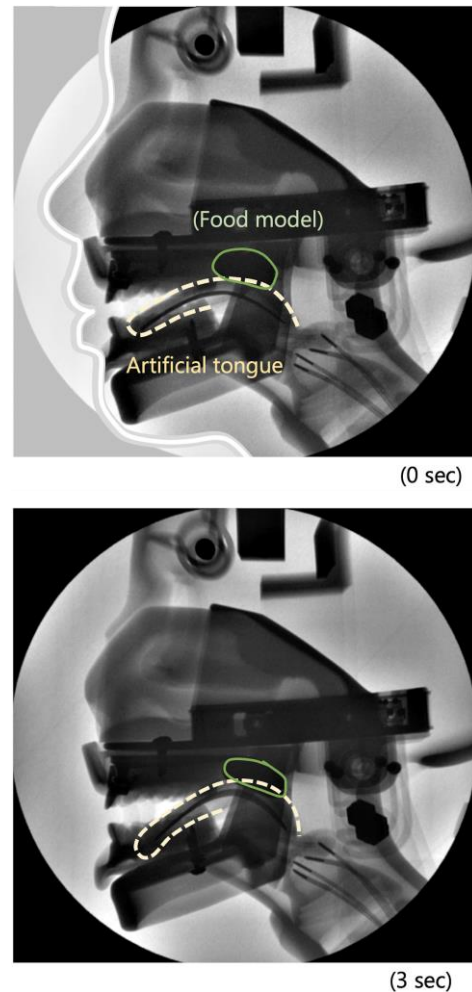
Demographic changes in the food analogue masses during the tongue motion derived by the X-ray investigation (top, dilatation phase at 0 sec; bottom, contraction phase at 3 sec): dashed line indicated the surface layer of the artificial tongue unit.
